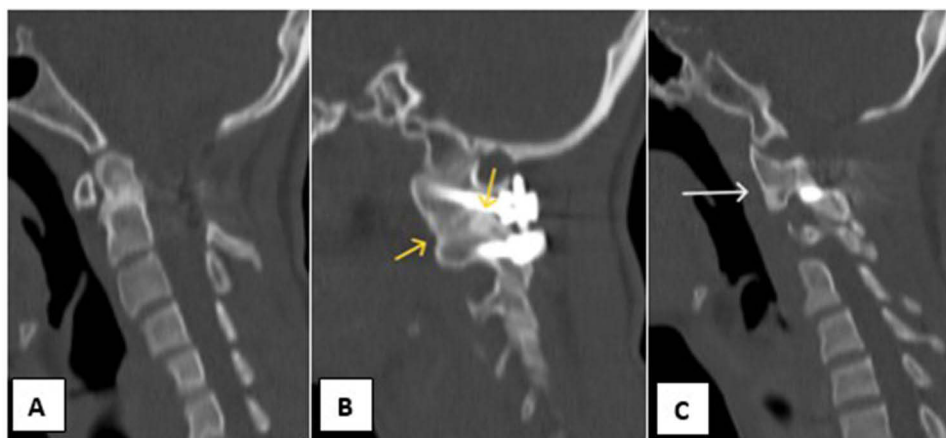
CT evaluation at one-year follow-up. Complete fusion of OF (A), normal alignment, anterior and posterior fusion mass (yellow arrows) on the left AAJ (B) and complete fusion (white arrow) in normally aligned position of the right AAJ (C).
